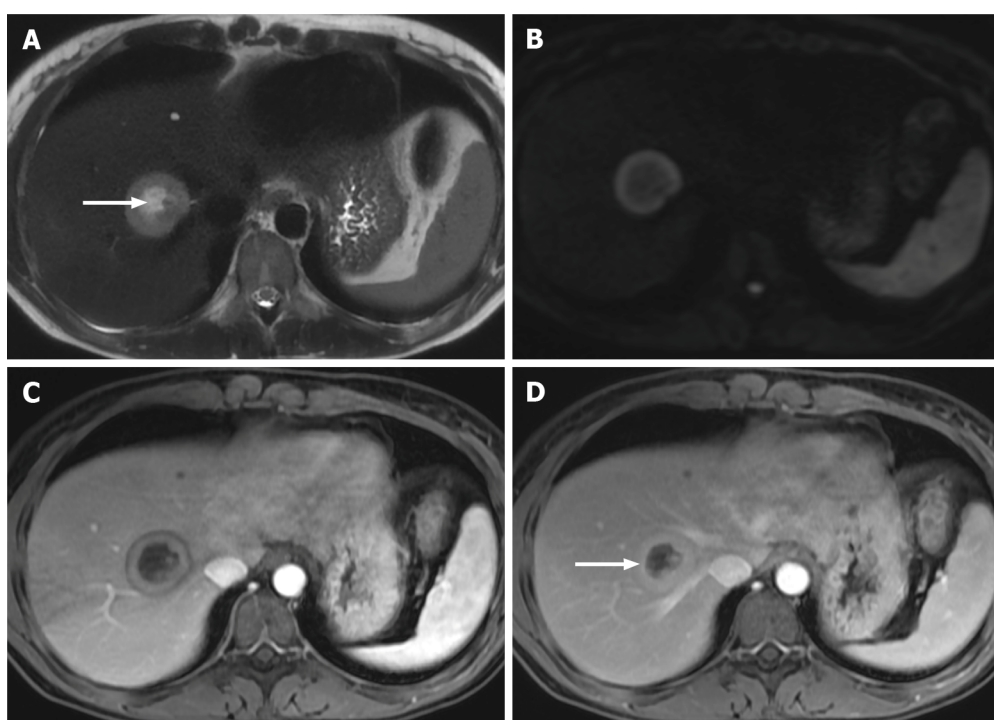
Right lobe liver metastasis from breast cancer. A: Axial T2-weighted imaging (WI) of the metastatic lesion shows a target sign characterized as a hyperintense center (arrow) - necrosis - margined by a lesser intense rim of viable tumor; B: Diffusion WI shows viable tumor characterized by an increased signal; C: Axial fat sat (FS) contrast-enhanced magnetic resonance imaging (CE-MRI) T1-WI in the arterial phase shows a characteristic doughnut sign; D: Axial FS CE-MRI T1-WI in the interstitial phase reveals a mild progressive enhancement of the peripheral tumor (arrow).
